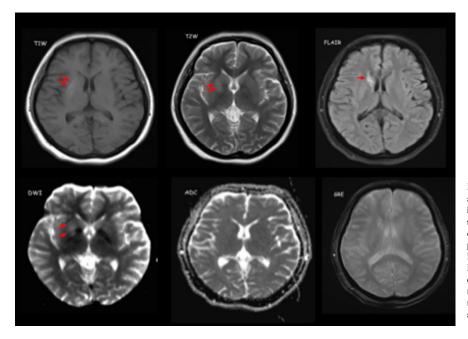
MRI: T1W, T2W and Fluid attenuated inversion recovery (FLAIR) images showed patchy hyperintense signals (red arrows) in the head of caudate nucleus, putamen and globus pallidus of the right internal capsule. Diffusion-weighted Imaging/Apparent Diffusion Coefficient shows no restricted diffusion, thus excludes acute ischaemia. Gradient Resonance Echo reveals no susceptibility artefact which is against acute haemorrhage.
